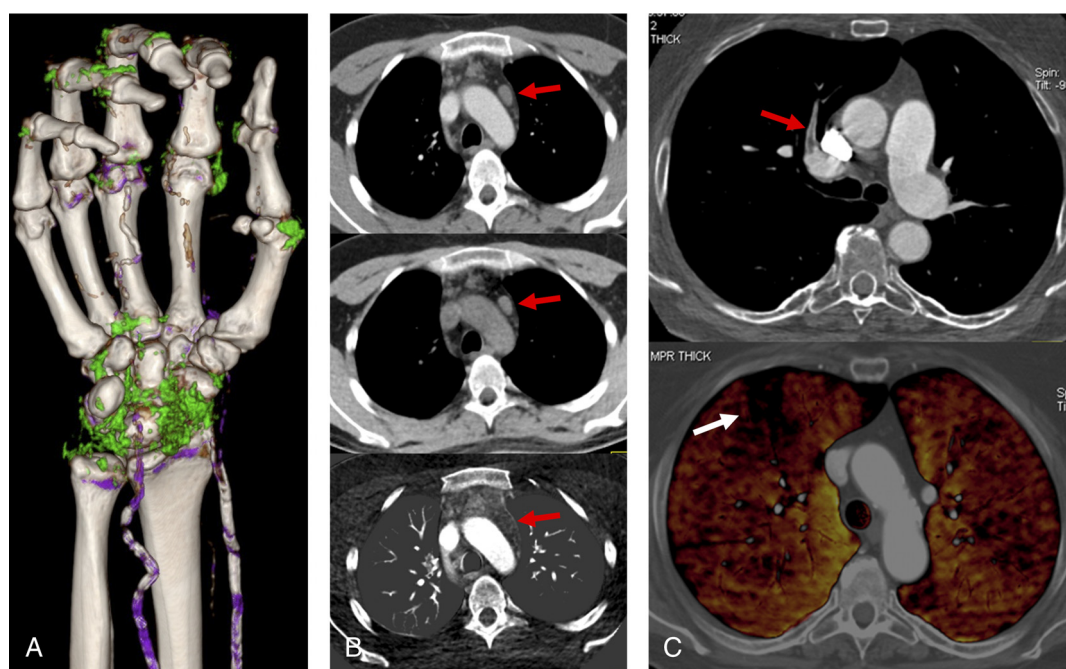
Typical examples of DECT. A, A 62-year-old patient with multiple urate deposits (coded in green color). Calcifications are coded in gray or purple (i.e., vessel walls). B, A 47-year-old patient after treatment of lymphoma. Persistent enlarged mediastinal lymph node (arrow) without contrast enhancement (upper row, 120-kV equivalent image; middle row, virtual nonenhanced image; bottom row, iodine map). C, A 68-year-old patient with acute pulmonary embolism. Embolic material (arrow) in CTA and the resulting perfusion defect (white arrow) in the color-coded iodine map (bottom row) can be visualized. Figure 7 can be viewed online in color at www.investigativeradiology.com.
